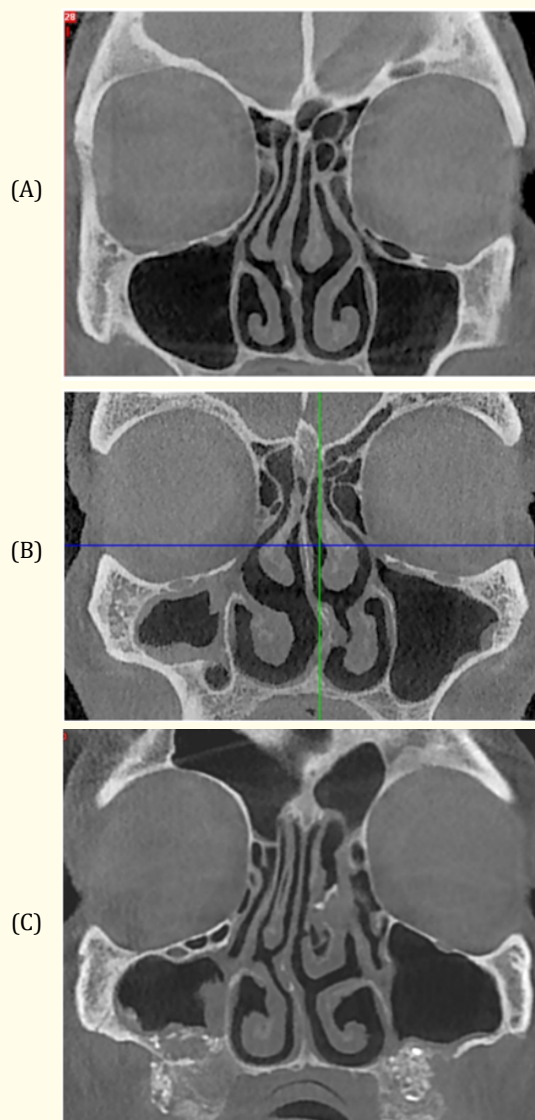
Coronal Sections of CBCT Images, Showing A) Left Haller's Cell and no Maxillary Sinusitis. B) Right Maxillary Sinusitis and No Haller's Cell. C) Right Haller's Cell and Right Maxillary Sinusitis.
